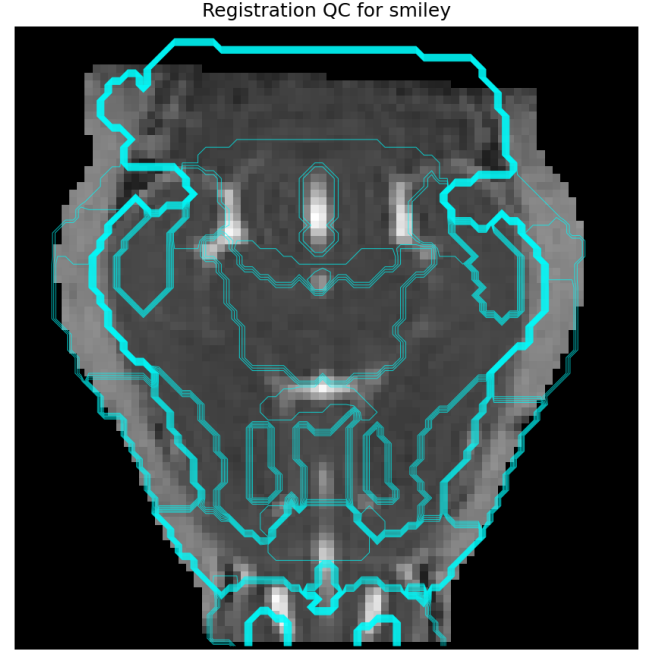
Visual quality control for brain atlas registration to a representative b0-weighted MR image. Overlaid cyan contours delineate the registered brain atlas, confirming accurate anatomical alignment crucial for reliable extraction of regional brain morphometric features.
